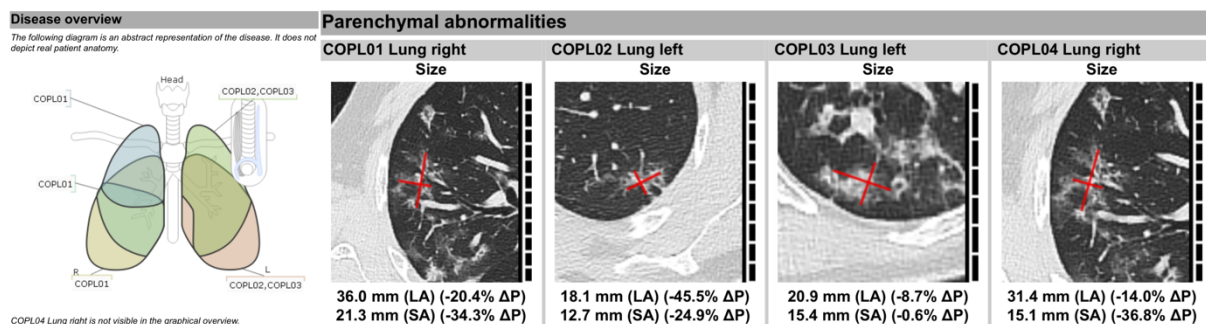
COVID-19 electronic case report form on mint lesion™ software platform. Here: Exemplary patient with confirmed COVID-19 pneumonia and chest CT at two subsequent time points. The patient was assessed and evaluated using the eCRF by an experienced radiologist. The assessment and evaluation are performed directly on primary imaging data and automatic rule-based evaluation of the disease progression. The patient was included in a clinical trial directly without the necessity of further data collection or twofold data documentation.
